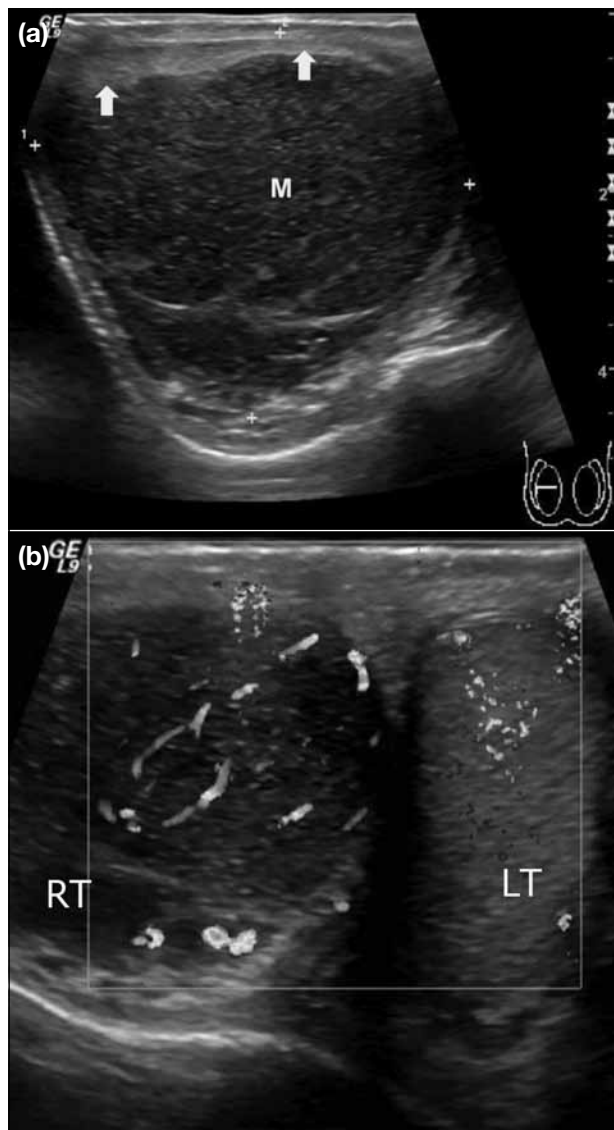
Primary testicular lymphoma with a solitary hypoechoic mass. A 79-year-old man presented with a painful right scrotal swelling: (a) transverse grey-scale ultrasonography (US) image of the right testis shows a large circumscribed hypoechoic mass (M) occupying almost the entire testis with compression of the normal echogenic testis (arrows); (b) transverse colour Doppler US image of both testes shows increased vascularity in the right testis (RT) and normal blood flow in the left testis (LT).
